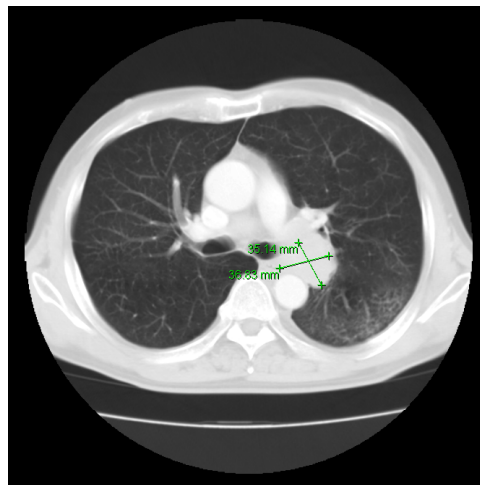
Chest CT showed tumor abutting to descending aorta in left hilum at Aug. 2009.
